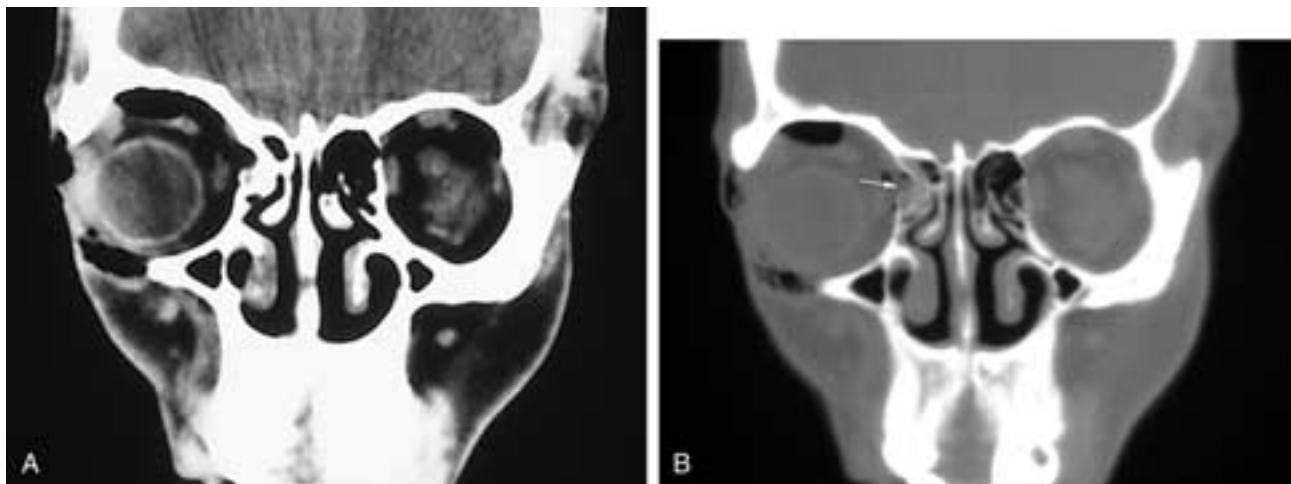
Coronal CT scans at soft-tissue (A) and bone (B) settings show a medial wall right blow-out fracture (arrow in B). There is also orbital emphysema. Note how much more difficult it is to detect the findings in (A).
